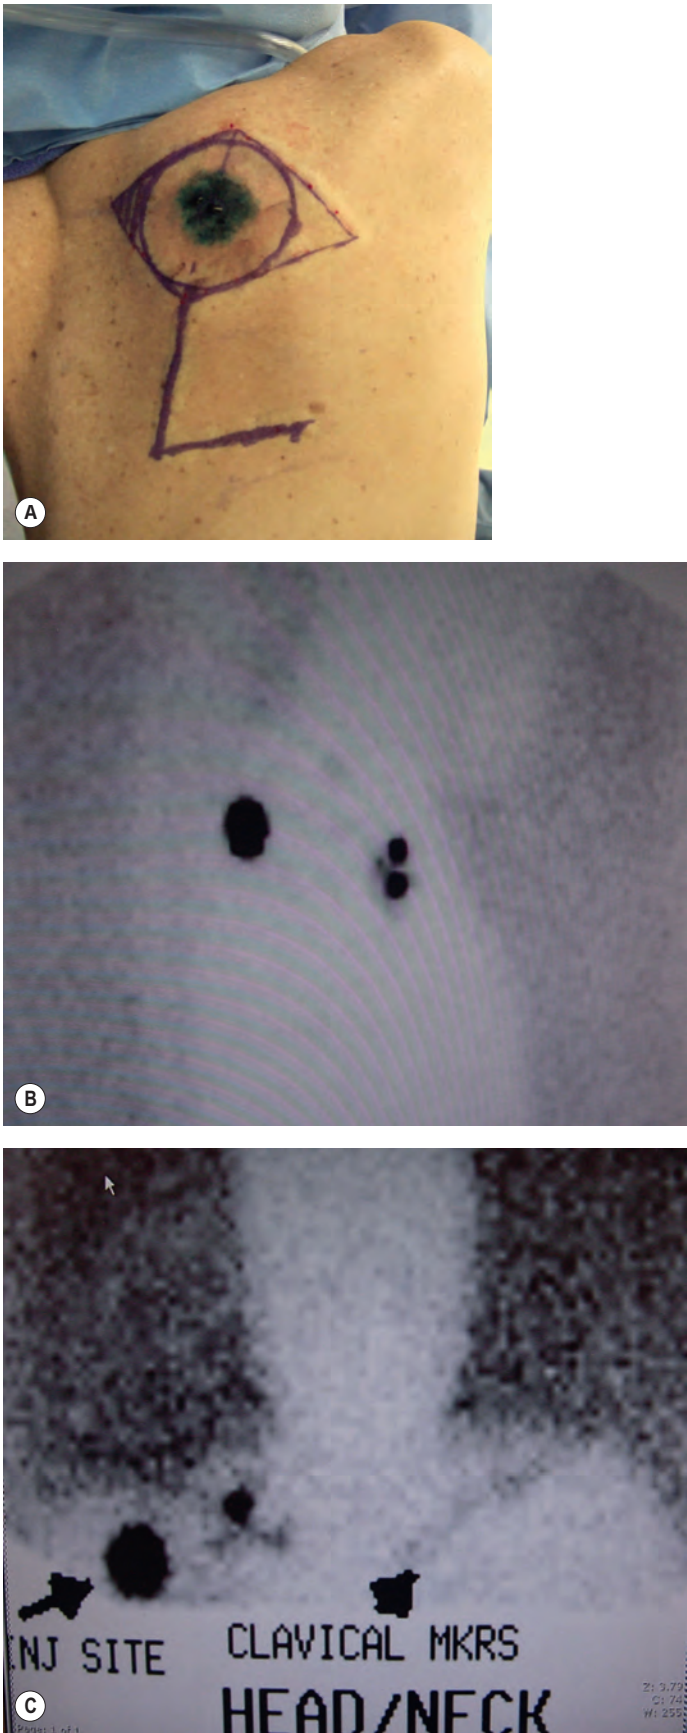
Lymphoscintigram of a right scapular melanoma (A) demonstrates drainage to the right axillary lymph nodes (B), as well as the right lower cervical nodes (C).
